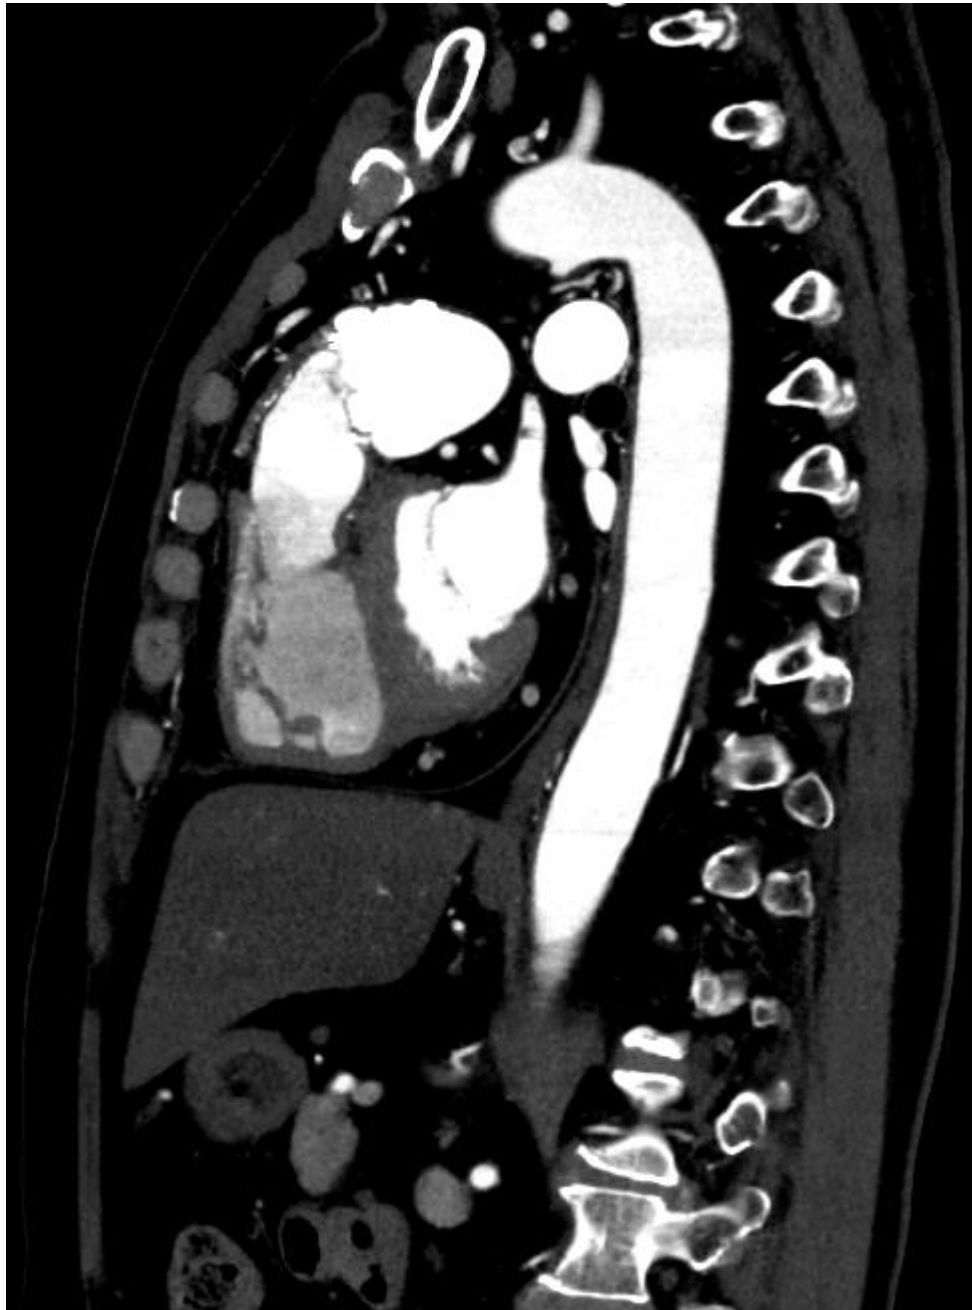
An enhanced computed tomography scan taken 4 months after onset shows no hematoma on the same slice view in the inferior mediastinum (A). A CT view shows no existence of unusual structures along ventral side of the descending aorta (B).
